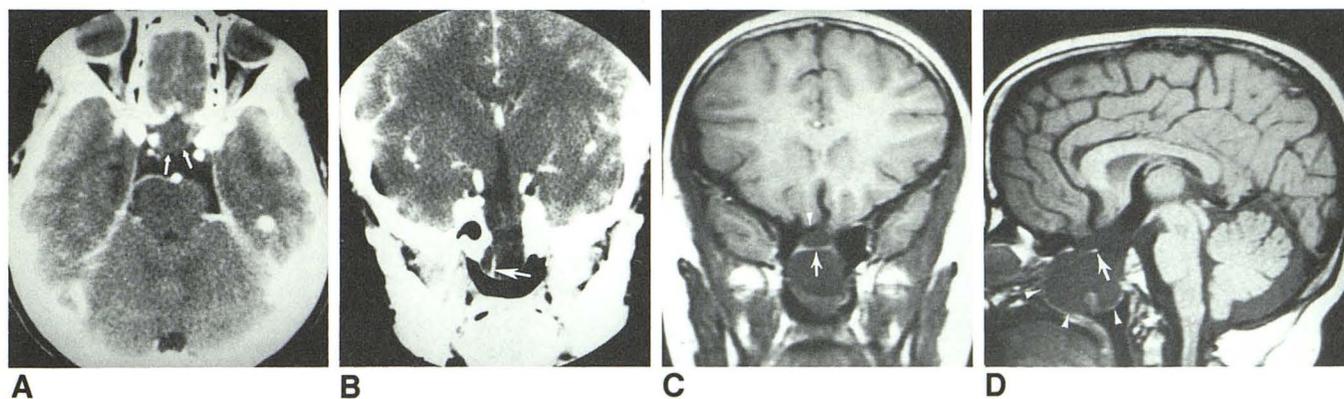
A, Axial enhanced CT shows a lesion of soft-tissue density within sella, slightly denser than CSF (arrows). B, Coronal enhanced CT image shows herniation of third ventricle inferiorly through sphenoid bone into epipharynx. Enhancement of infundibular stalk can be seen inferiorly in encephalocele (white arrow). C, Coronal MR (SE 800/20) shows optic chiasm (arrow) displaced inferiorly within encephalocele. Lateral to chiasm and encephalocele wall, internal carotid arteries and aerated sphenoid bone can be seen as regions of signal void. A1 segment of right anterior cerebral artery lies just above encephalocele (arrowhead). D, Sagittal MR (SE 800/20) shows inferior extension of third ventricle into encephalocele. Ptotic optic chiasm (arrow) is somewhat thin. Encephalocele bulges into epipharynx (arrowheads).
